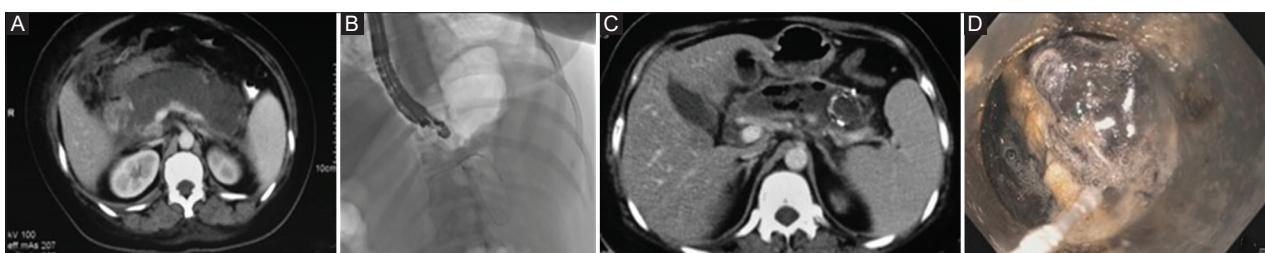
(A) Computed tomography at day 19: an ill-defined pancreatic necrosis. (B) LAMS being deployed. (C) Computed tomography after metal stent placement. (D) Cap-assisted endoscopic necrosectomy
